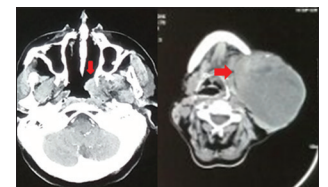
Computed tomography images showing mass in the nasopharynx and submandibular region
